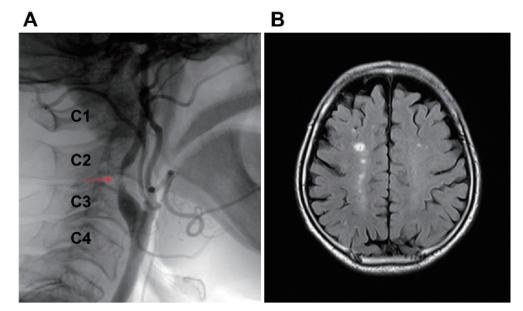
Preoperative images. (A) Angiography showing stenosis (arrow in red) of the cervical portion of the right internal carotid artery from the superior margin of the C3 vertebral body to the midline of the C2 vertebral body. Stenosis is 80% according to the North American Symptomatic Carotid Endarterectomy Trial criteria. (B) Preoperative cerebral fluid-attenuated inversion recovery magnetic resonance imaging showing an old cerebral watershed infarction of the right frontal centrum semiovale. The red arrow indicates the point of stenosis.
